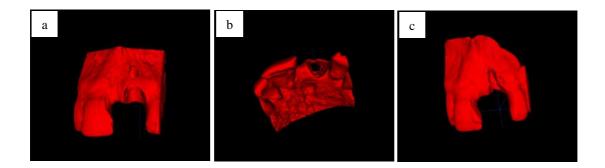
Three CBCT volume rendering reconstructions demonstrating vertical and horizontal tissue loss following tooth extraction. a) and b) Socket shape immediately after the extraction. c) alveolar bone contour at 4 months healing.
